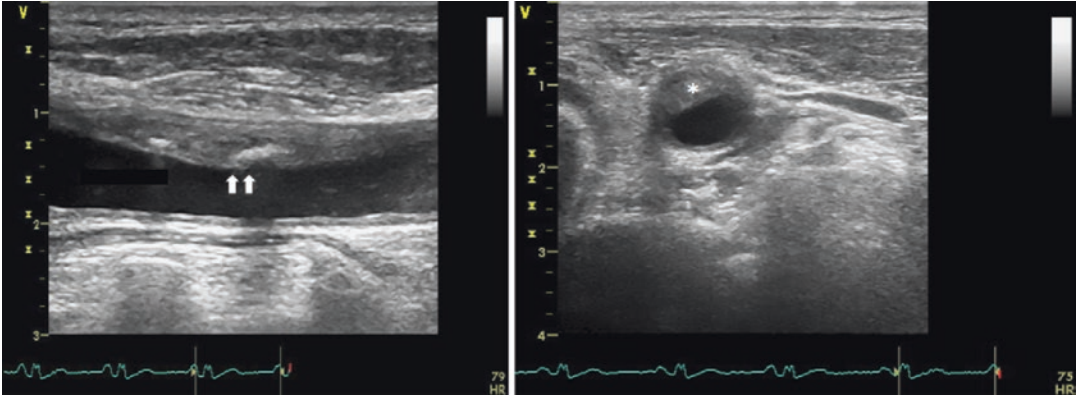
Carotid plaque detected by carotid ultrasound
